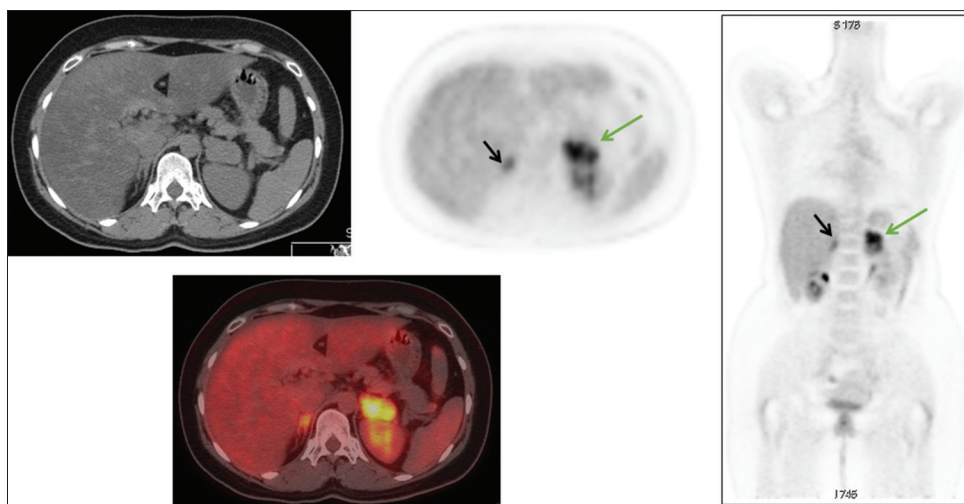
Axial computed tomography, positron emission tomography, positron emission tomography/computed tomography, and coronal positron emission tomography of a patient with biopsy-proven left adrenal metastases (green arrows) diagnosed 2 years post left modified radical mastectomy (MRM) and chemoradiotherapy. →There is also mild fluorodeoxyglucose uptake noted at the site of the normal-looking right adrenal gland (black arrows) that could be physiological
